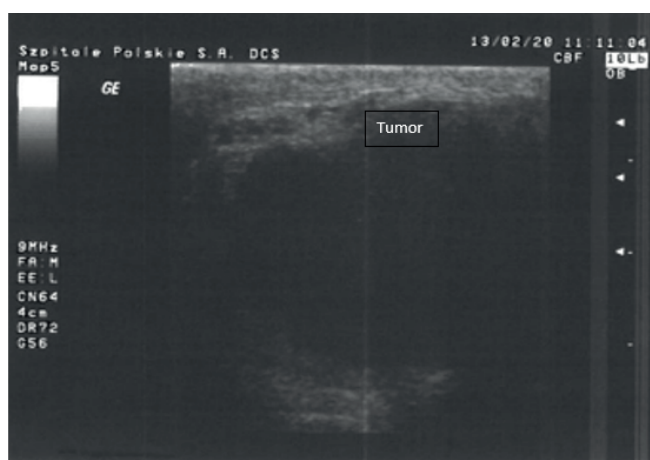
Ultrasound showed the tumor of irregular shape
